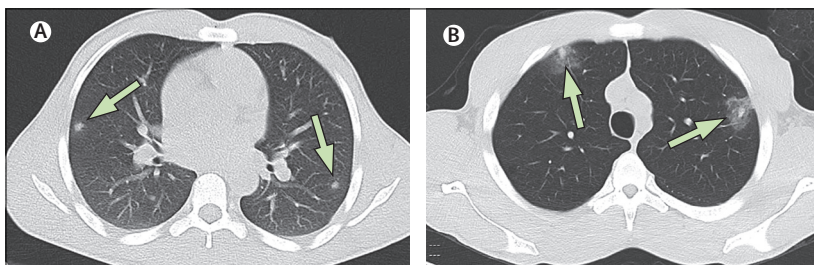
Lung nodules at CT scan
